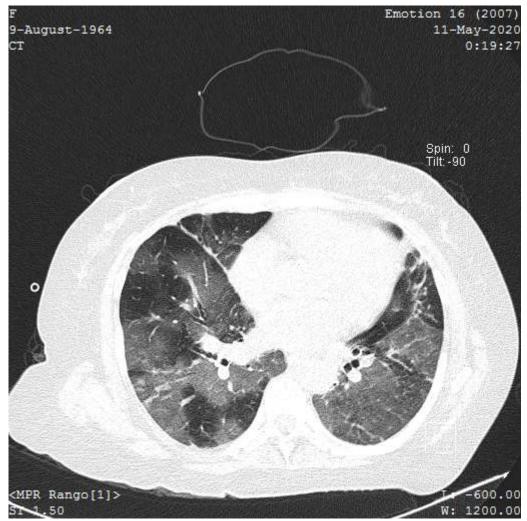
Chest CT-scan of a 56-year-old woman with confirmed COVID-19 pneumonia. Representative axial thin-section chest CT image showing focal confluent ground-glass opacities with diffuse reticular septal thickening. The calculated Computed Tomography Severity Index was 23.
